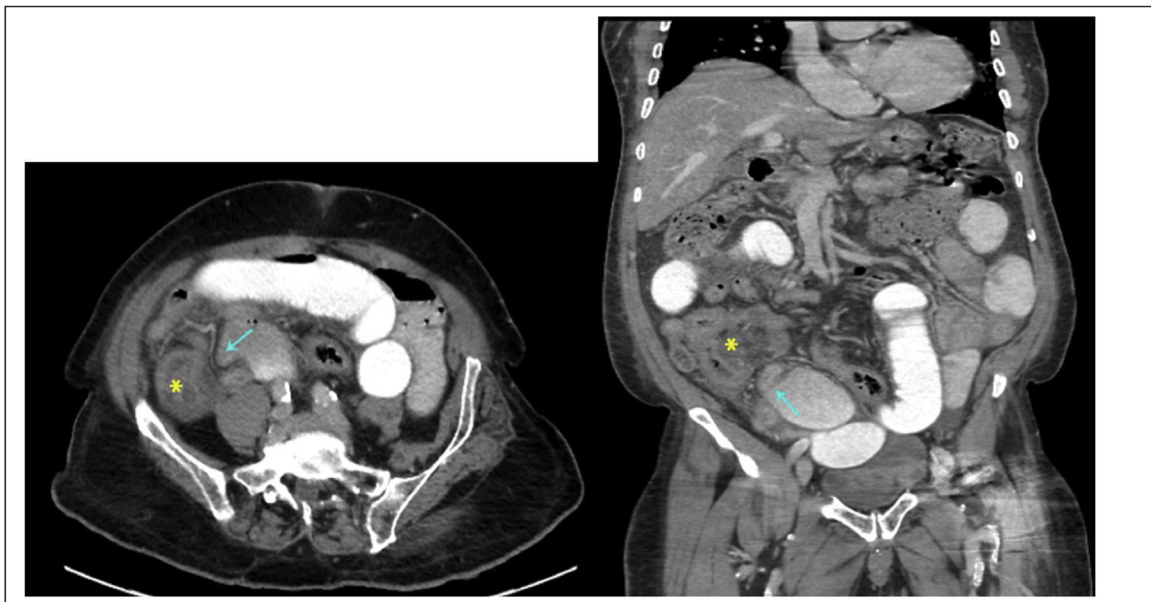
CT abdomen axial views show small intestinal obstruction, with the transitional zone (arrow) at the cluster of inflamed distal ileal loops close to the cecum and ileocecal valve (asterisk); there are adjacent small loculated collections.
